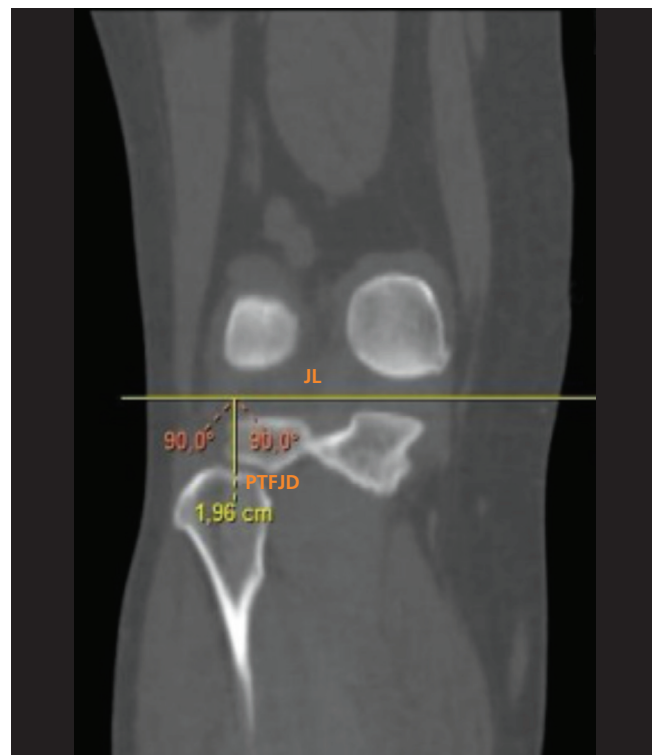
Coronal CT image. Proximal tibio-fibular joint distance (PTFJD) is the distance between JL and the center of the horizontal portion of the proximal tibiofibular joint.
